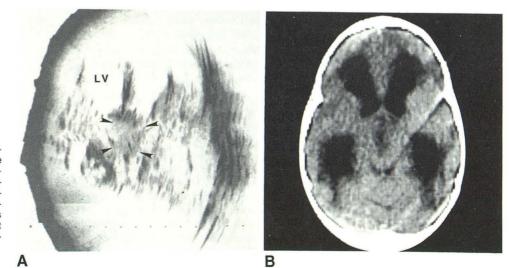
Case 6, suprasellar astrocy-toma. A, Axial sonogram shows subtle echogenic mass in suprasellar area (arrowheads) without significant displacement of adjacent structures. Lateral ventricles (LV) moderately dilated. B, Precontrast CT scan shows suprasellar mass that enhanced slightly on postcontrast scan (not shown) and moderate enlargement of lateral ventricles.
